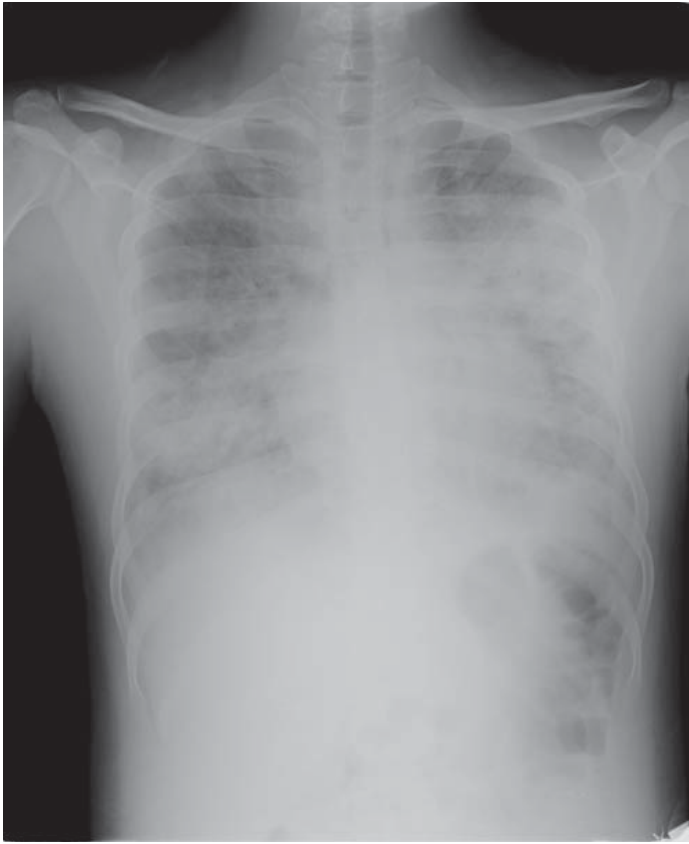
Radiograph (anteroposterior view) of patient with acute respiratory distress syndrome and oseltamivir-resistant pandemic (H1N1) 2009 virus.
